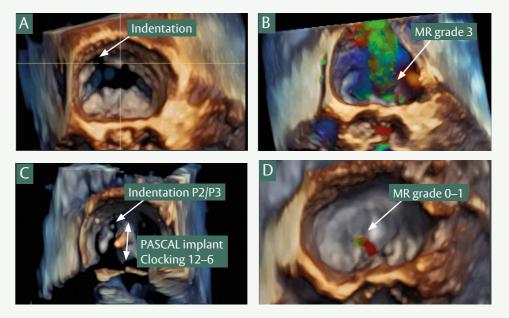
3D echocardiography of the mitral valve showing the indentation between the P2 and P3 segments (A), the MR jet pre procedure (B), the PASCAL implant in position (C) and the MR jet post implantation of the PASCAL implant (D). MR, mitral regurgitation.
